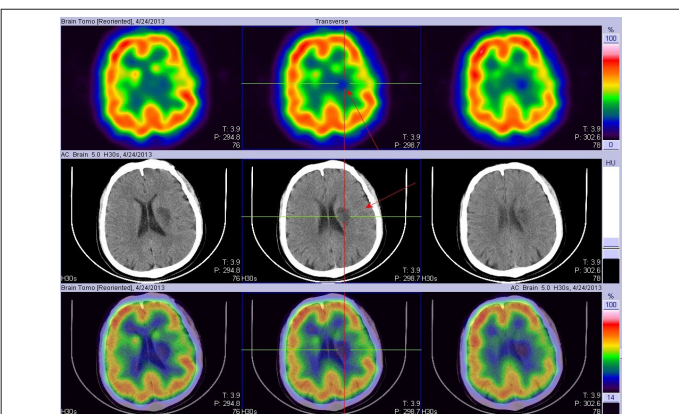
SPECT shows a radiotracer defect in the left basal ganglia and corona radiata, while the simultaneous CT shows reduced density in this SPECT shows reduced cerebral blood flow perfusion in the left parietal and temporal lobes, whereas CT shows no obvious abnormal density changes in this area.
